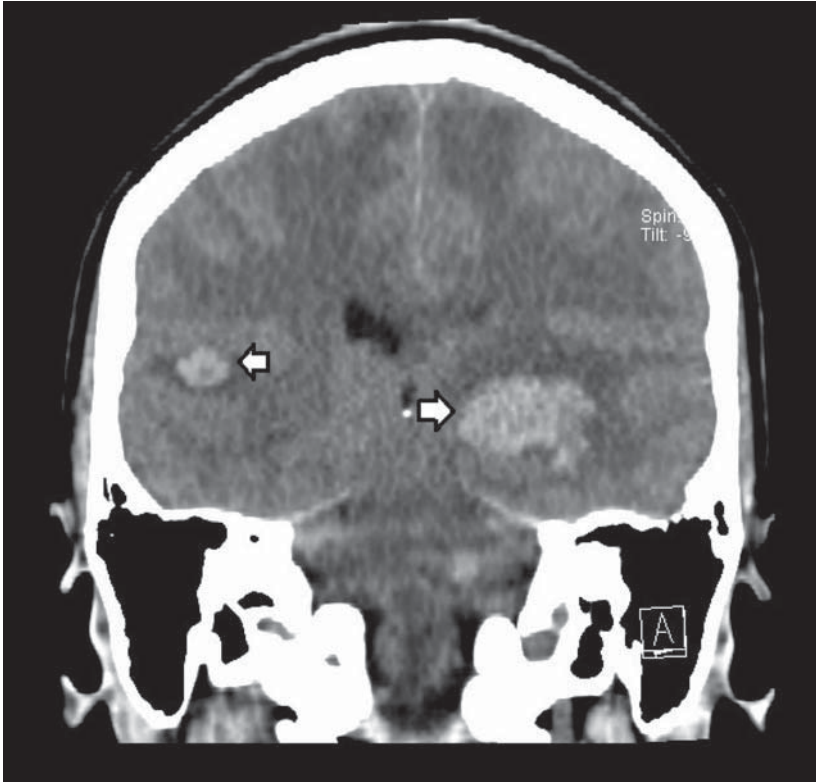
Brain computed tomography scan without contrast enhancement. Two large areas of intraparenchymal haemorrhage are evidenced.
